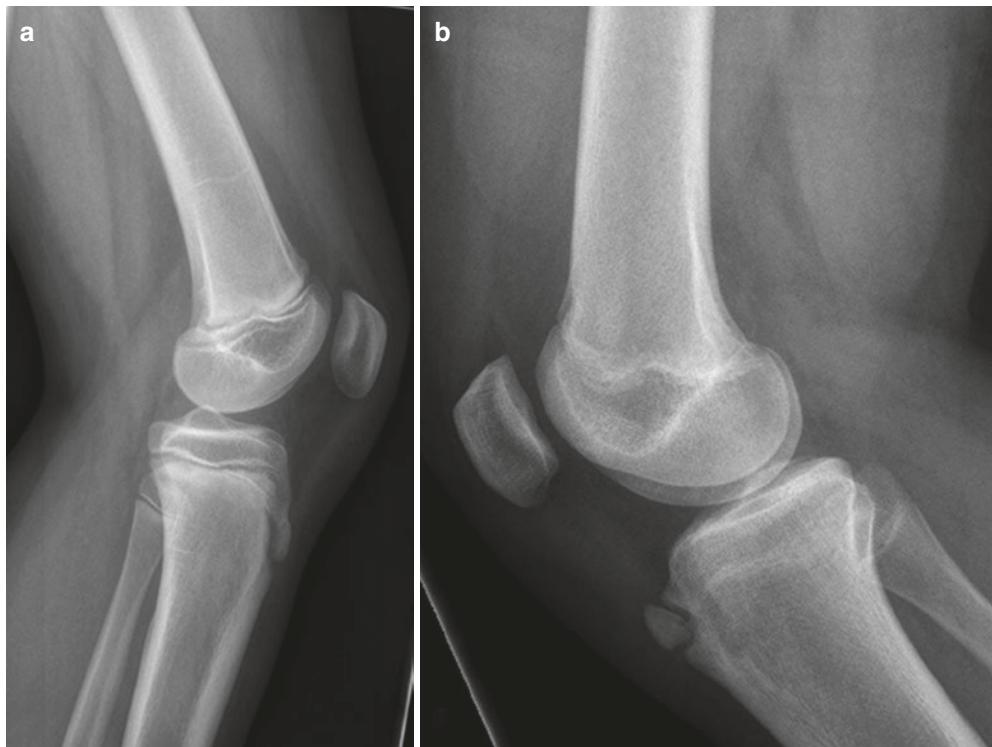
Lateral radiographs of the knee. (a) A 9-year-old boy, showing a normal appearance of the tibial tuberosity and patellar tendon. (b) A 12-year-old girl, showing
